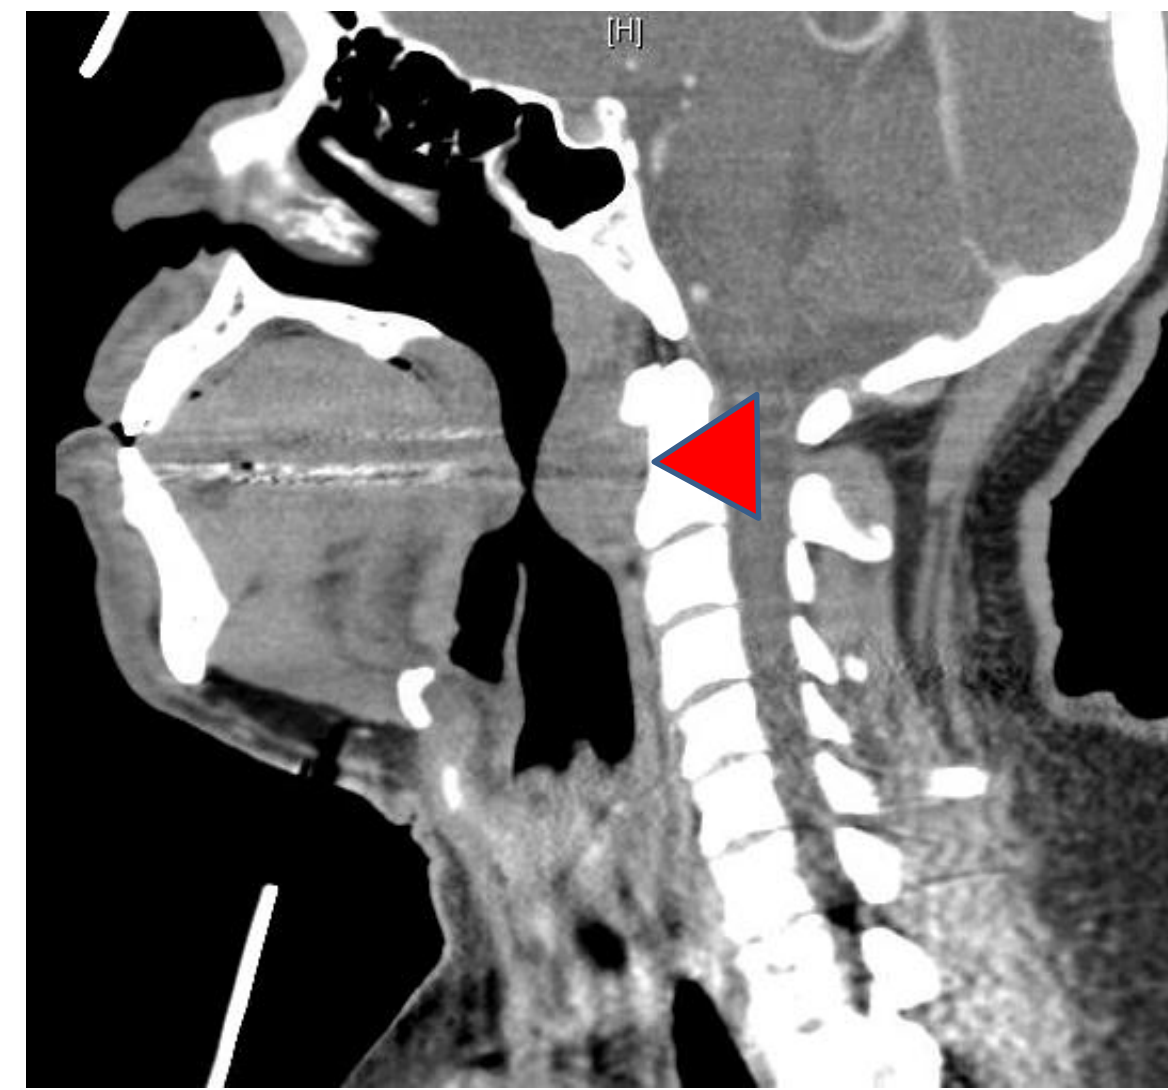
CT neck with contrast with sagittal view, soft tissue window. Arrow marks prevertebral mass.
